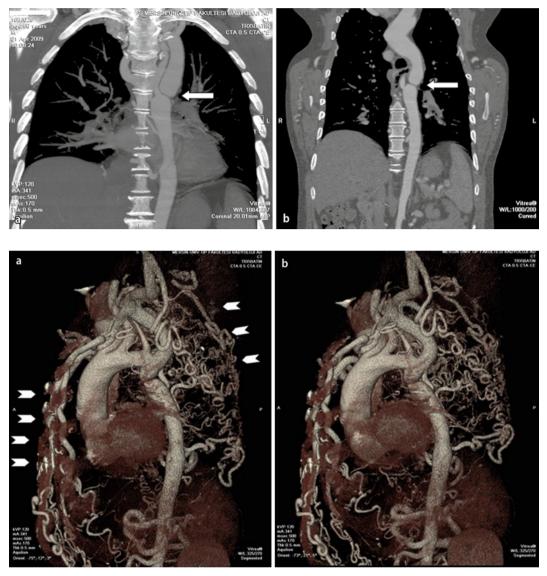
◀ a, b Contrast-enhanced, three-dimensional computed tomography angiogram reveals severe hypoplasia of the aortic arch (*arrow*) distal to the origin of the left subclavian artery (interrupted aortic arch, type A)
